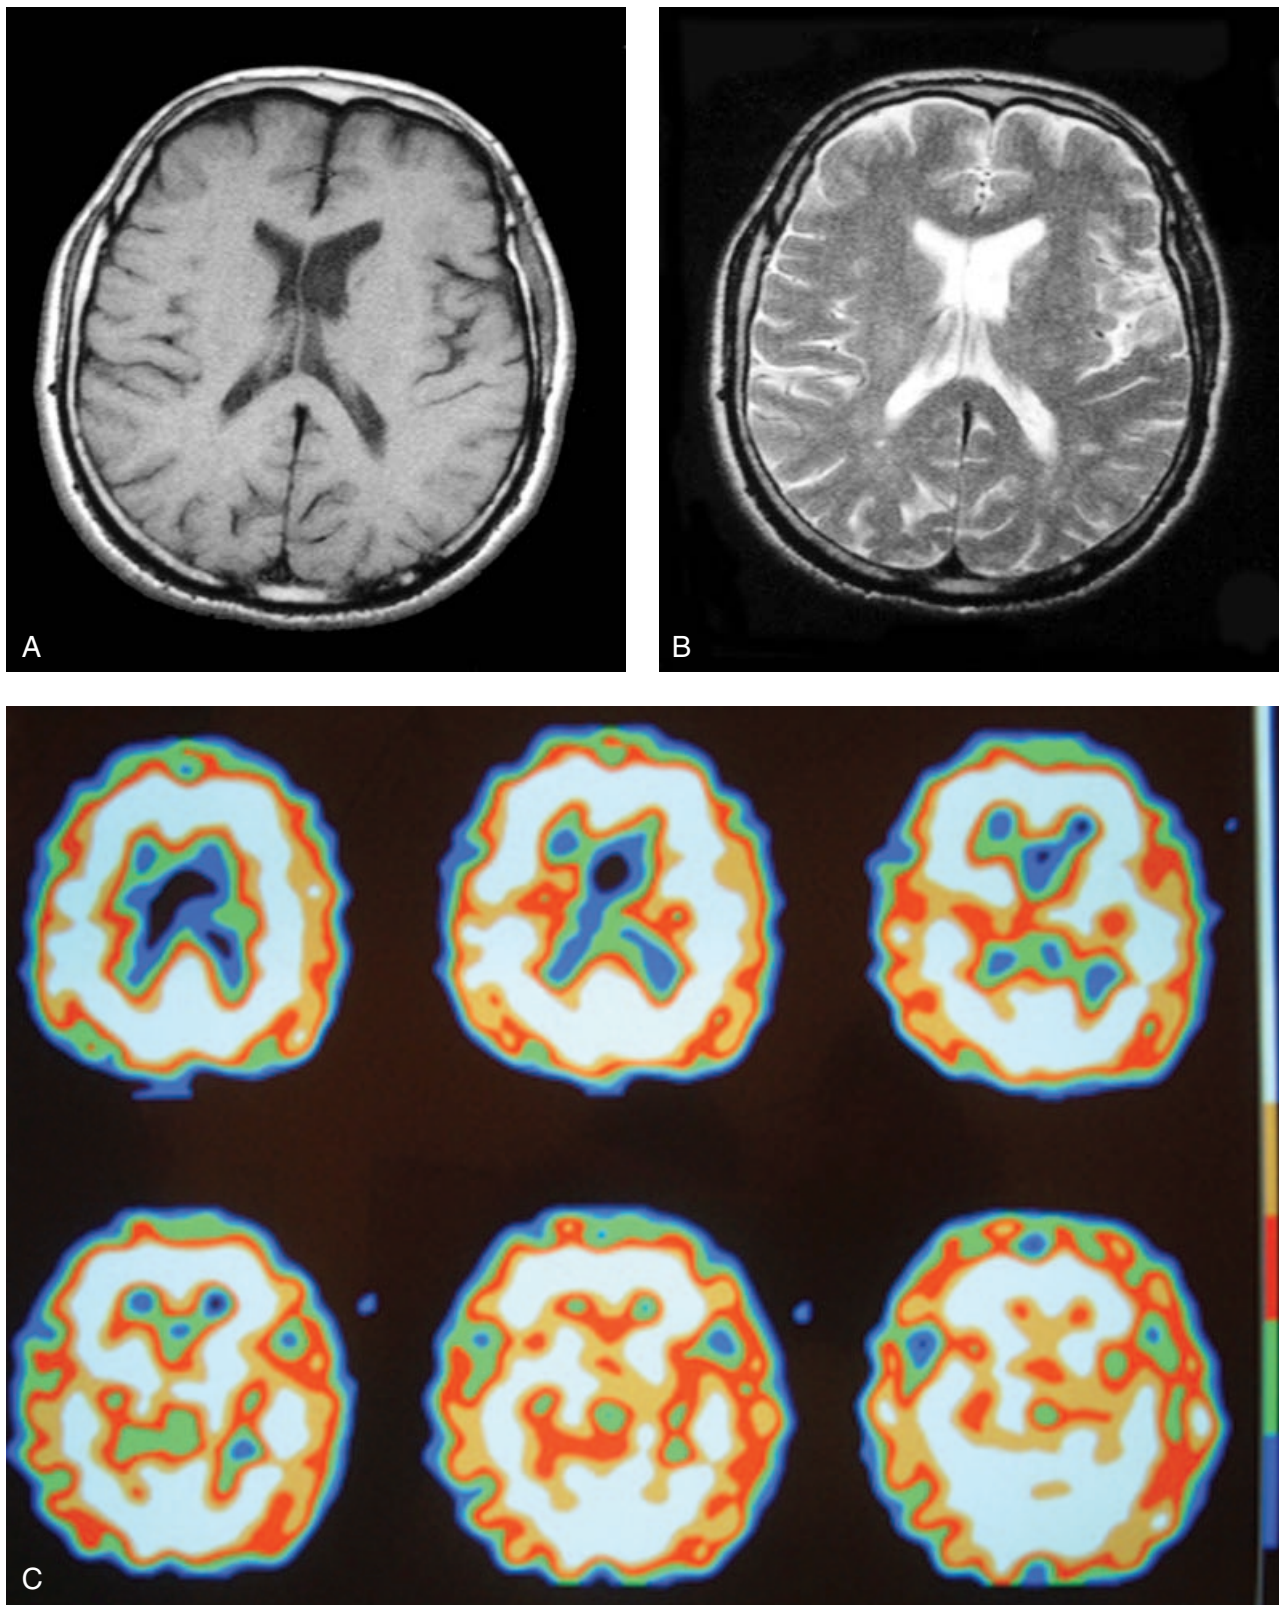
Moderate perfusion defect. A. No signal abnormalities can be seen on the T1-weighted MR image. B. On the T2-weighted image, a hyperintense lesion can be seen clearly in the insular region. C. Axial HMPAO brain SPECT images show moderate hypoperfusion in the insular region of the left hemisphere.
